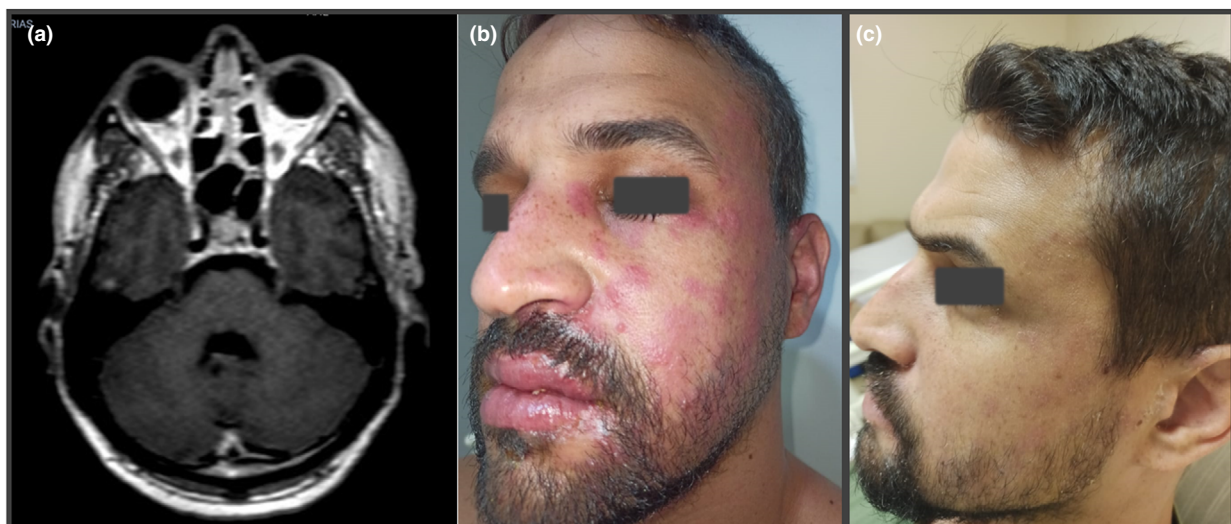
Trigeminal neuropathy due to zoster virus in a COVID-19 positive patient. (a) Admission day, when MRI evinced left trigeminal enhancement (axial CUBE T1WI + contrast sequence). (b) Facial cutaneous lesions in the three divisions of trigeminal nerve. (c) Reduction of vesiculopapular rash and crusted lesions. [Colour figure can be viewed at wileyonlinelibrary.com]
